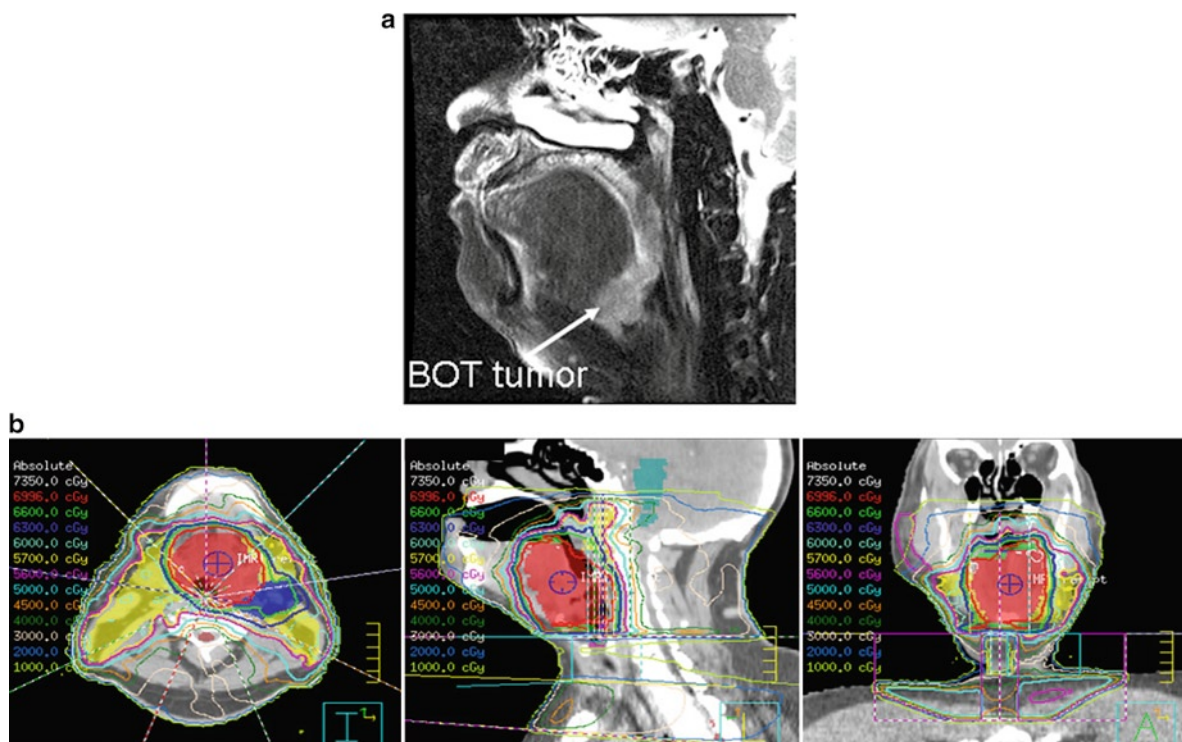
Base of tongue tumor (a) Initial T2-weighted MRI appearance of a T3 N1 base of tongue squamous cell carcinoma (b) IMRT treatment plan for definitive chemoradiation of this lesion to a dose of 70 Gy in 33 fractions
